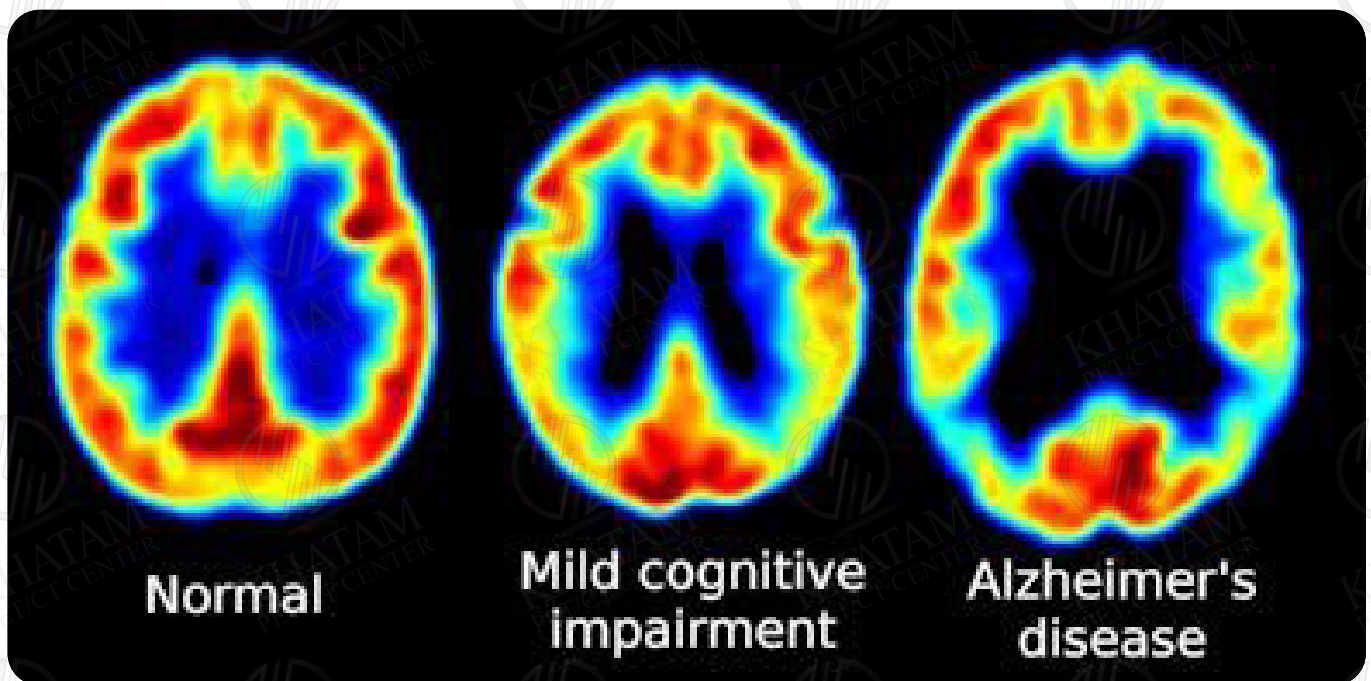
^{18}F -FDG PET images show reduced glucose metabolism in temporal and parietal regions in patients with MCI and Alzheimer's
